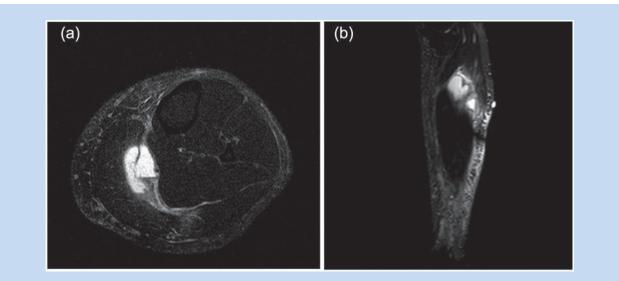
(a) and (b) Axial and sagittal T2-weighted magnetic resonance images demonstrate a fluid collection at the musculotendinous junction of the medial head of the gastrocnemius correlating with a tear.
